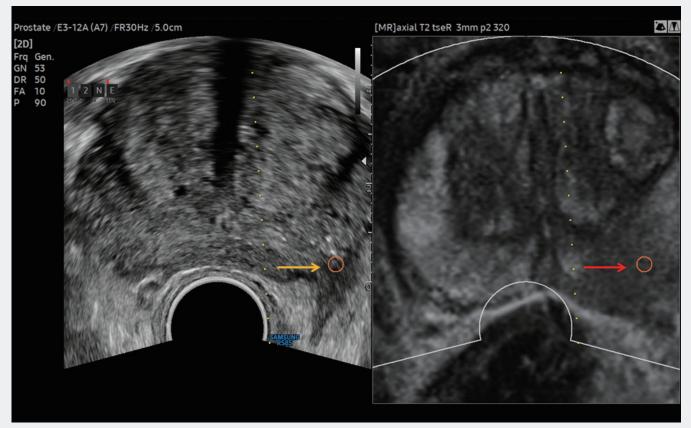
Image fusion of the prostate: Suspected small low-echo lesion (yellow arrow) of the prostate in conventional B-image sonography and in MRI imaging a signal-lowered (hypointense) carcinoma suspected lesion in the peripheral zone on the left (red arrow). In the registered MRI image fusion, the prostate is recorded in the axial MRI plane.
